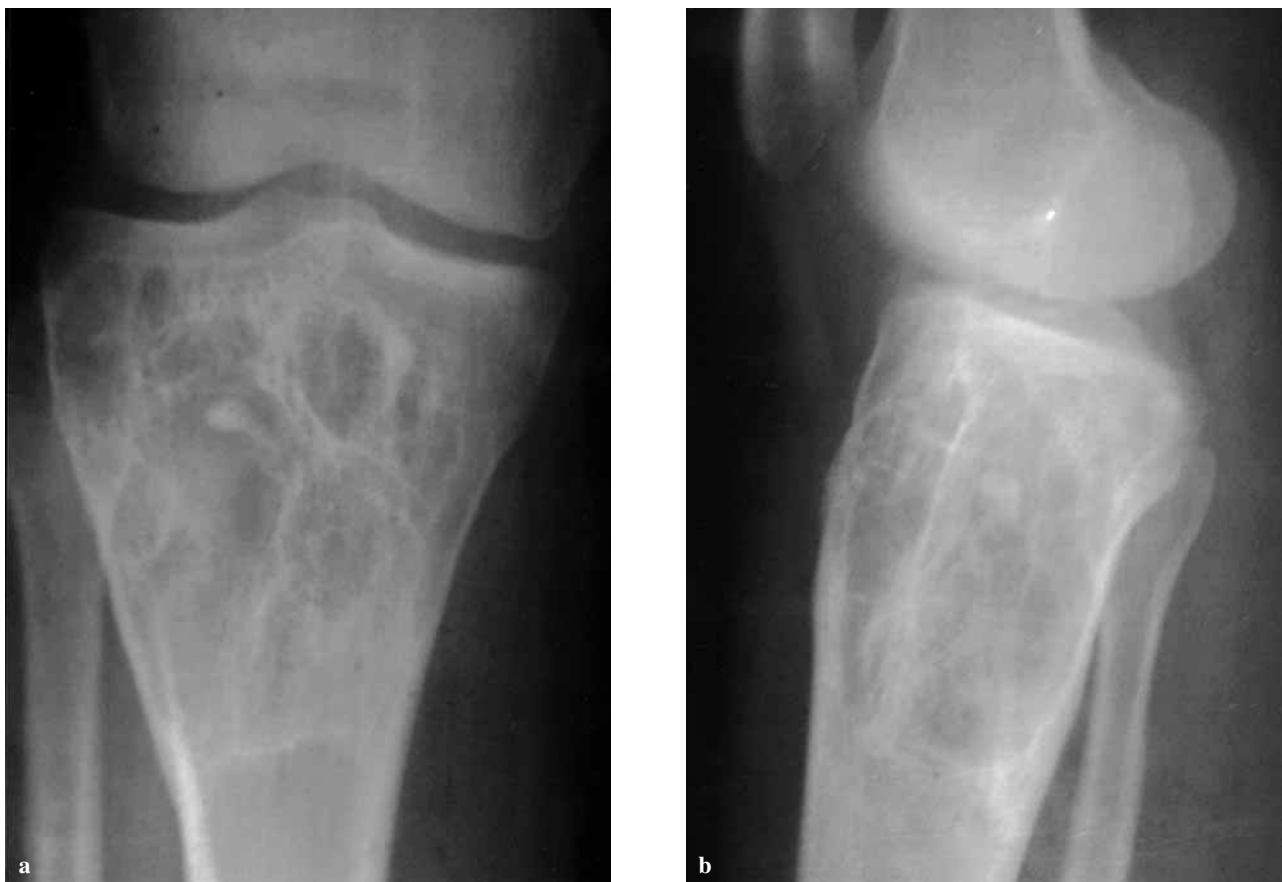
a,b*. — AP (a) and lateral (b) plain radiographs of the proximal tibia in a 51-year-old woman : intraosseous lipoma
